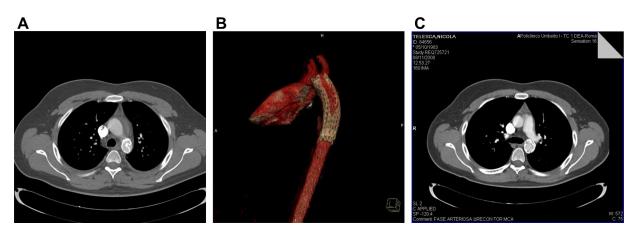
A, A 5-year computed tomographic angiogram (CTA) control that shows an infolding of thoracic aorta endograft. B, Three-dimensional reconstruction of the infolding of thoracic aorta endograft. C, Endovascular treatment by an adjunctive cuff of the infolding of the endograft depicted in (A) and (B).
